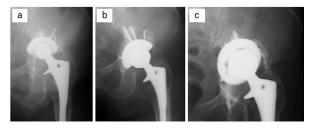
Case 3. Anteroposterior radiographs of the left hip at 19 years after primary THA (a), immediately after the first acetabular revision (b), and 6 years after the revision (c).
